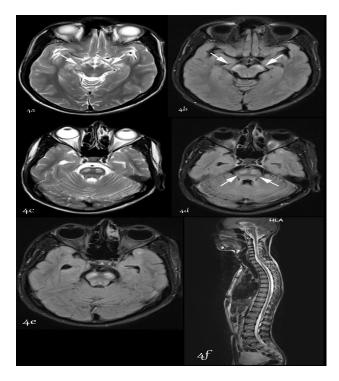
Follow up MRI of brain and spinal cord in index patient showing symmetrical signal hyperintensity involving cerebral peduncle of mid brain (a, b), pons (c, d, e) in T2 and flair and atrophy of thoracic segment of spinal cord (f) in T2 image.
